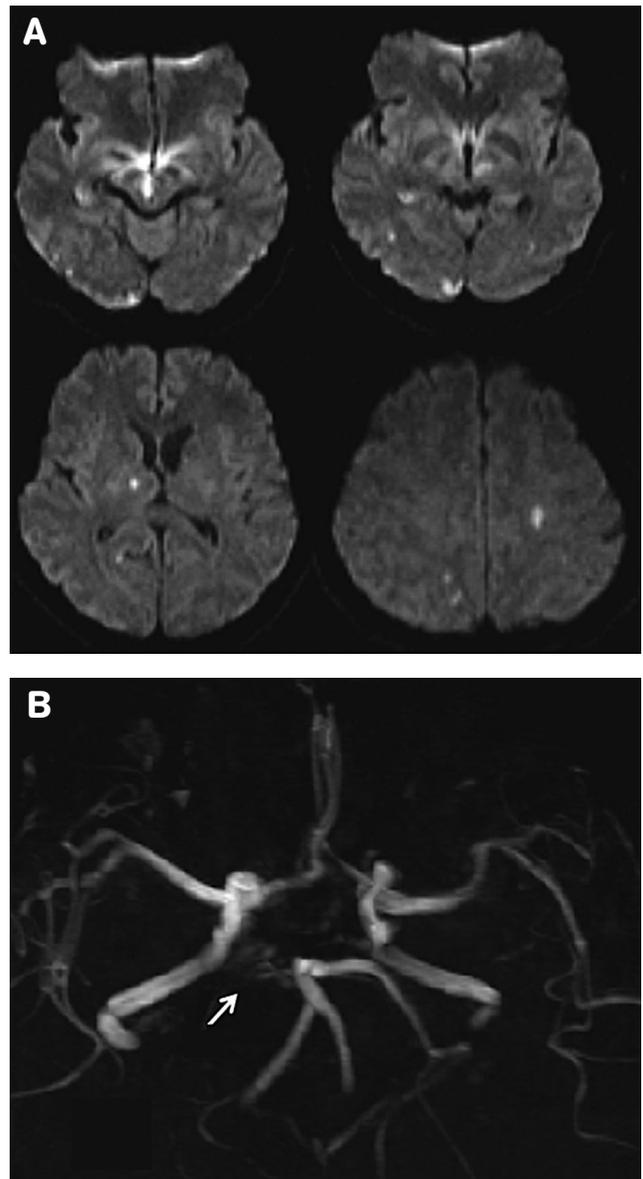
(A) MRI diffusion weighted imaging on the second stroke shows new small infarcts over the right central midbrain, occipital cortex, thalamus, and bilateral subcortical white matter. (B) MR angiography reveals decreased flow in the right posterior cerebral artery (arrow).
